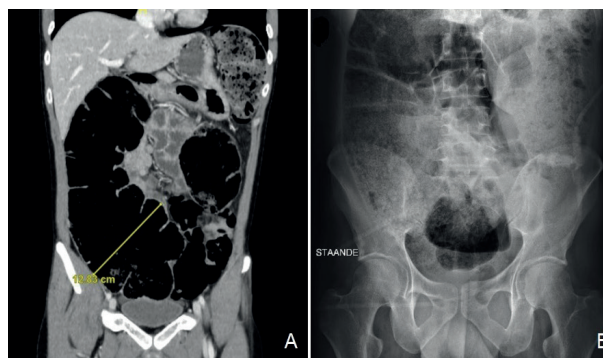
(A) CT shows a distended colon with a caecal diameter of > 12 cm. (B) Reoccurrence of colonic distention after endoscopic decompression, for which a new colonoscopy with desufflation was performed.
